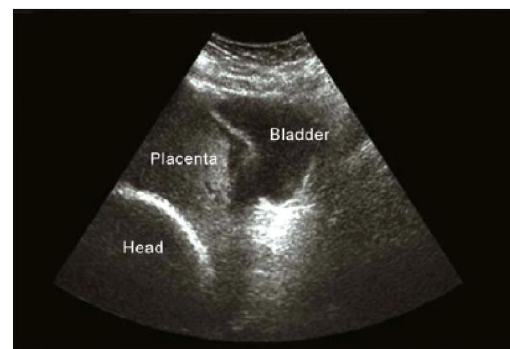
Ultrasound image shows disruption of the posterior bladder wall-uterine interface.
